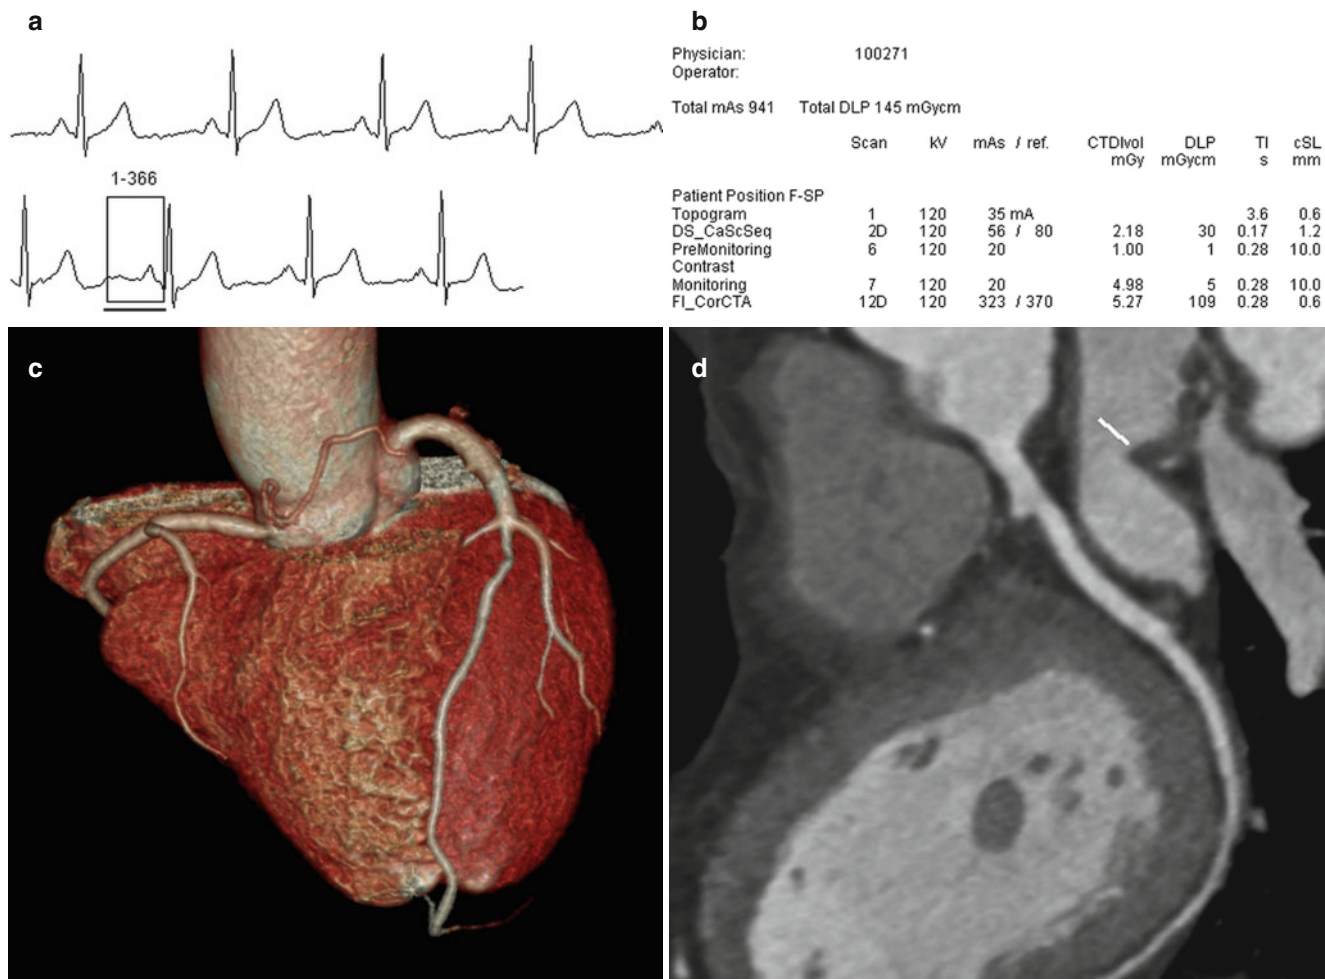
High pitch technique (Flash-mode, Siemens). (a) In a patient with 58 bpm of heart rate. CT images are acquired in only one heart beat. (b) The total effective radiation dose of the CT examination
